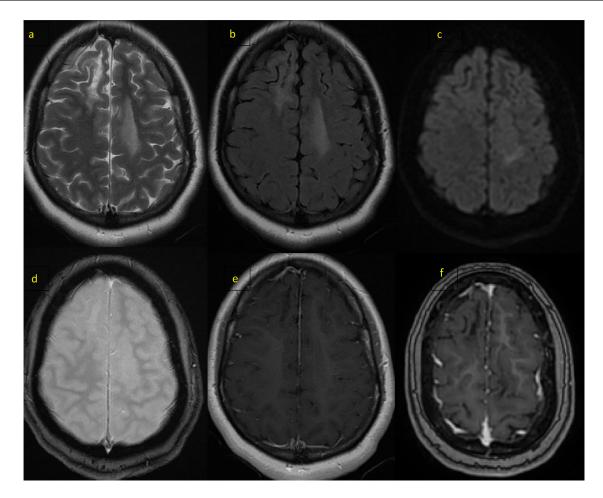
Six months follow-up axial Brain MRI after cortico-steroid treatment: Large bilateral frontals lesions hyperintense on T2 (A), FLAIR (B) et DWI (C), without any loss of signal on T2\* (D). It enhances with a discontinuous ring pattern in gradient T1 MPRAGE (E) and fast-spin echo T1 FSE (F).
